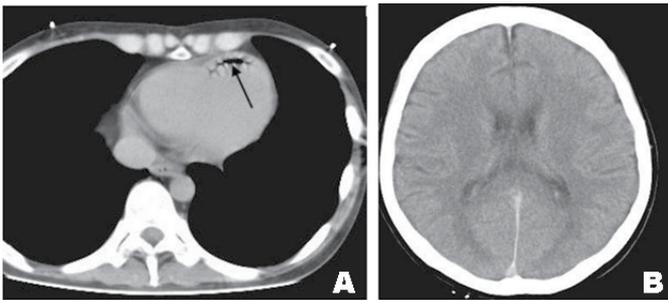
Central venous catheter- related cerebral arterial paradoxical embolism. (A) Left ventricular gas (arrow) on MDCT. (B) No gas was shown on head CT, but symmetrical hyperintensity was shown in bilateral occipital lobes on diffusion weighted magnetic resonance image (not shown).
